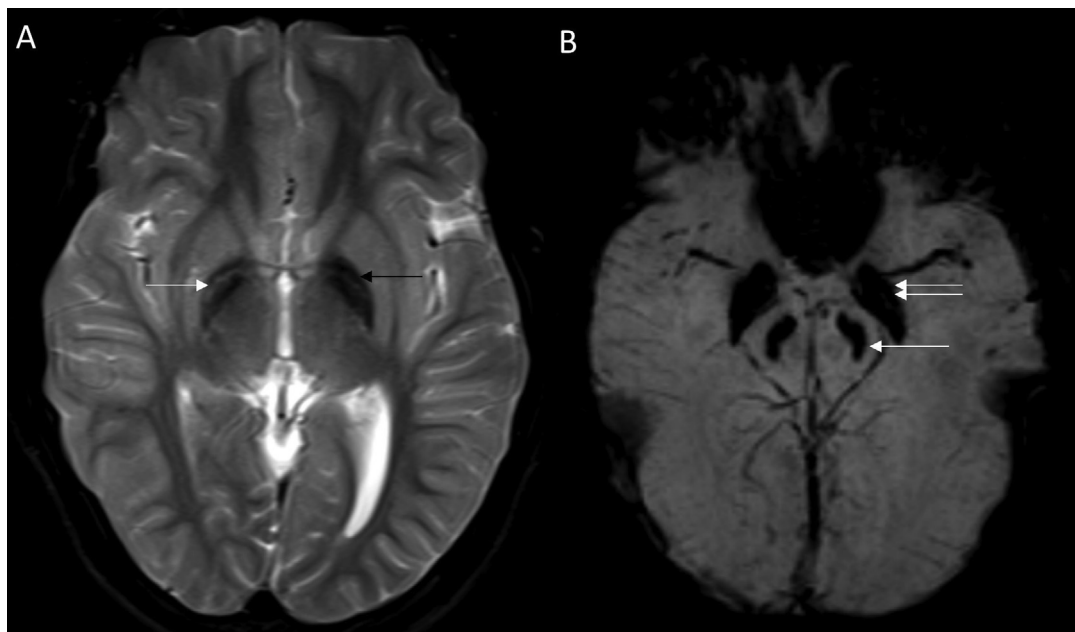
MRI brain T2 axial (A) image of the elder sibling showing bilateral symmetric hypo intensity of the globi pallidi (black arrow) with faint hyper intensity of medial medullary lamina (white arrow). SWI image (B) showing hypo intensity and blooming of globus pallidus (double arrows) and substantia nigra (white arrow).
